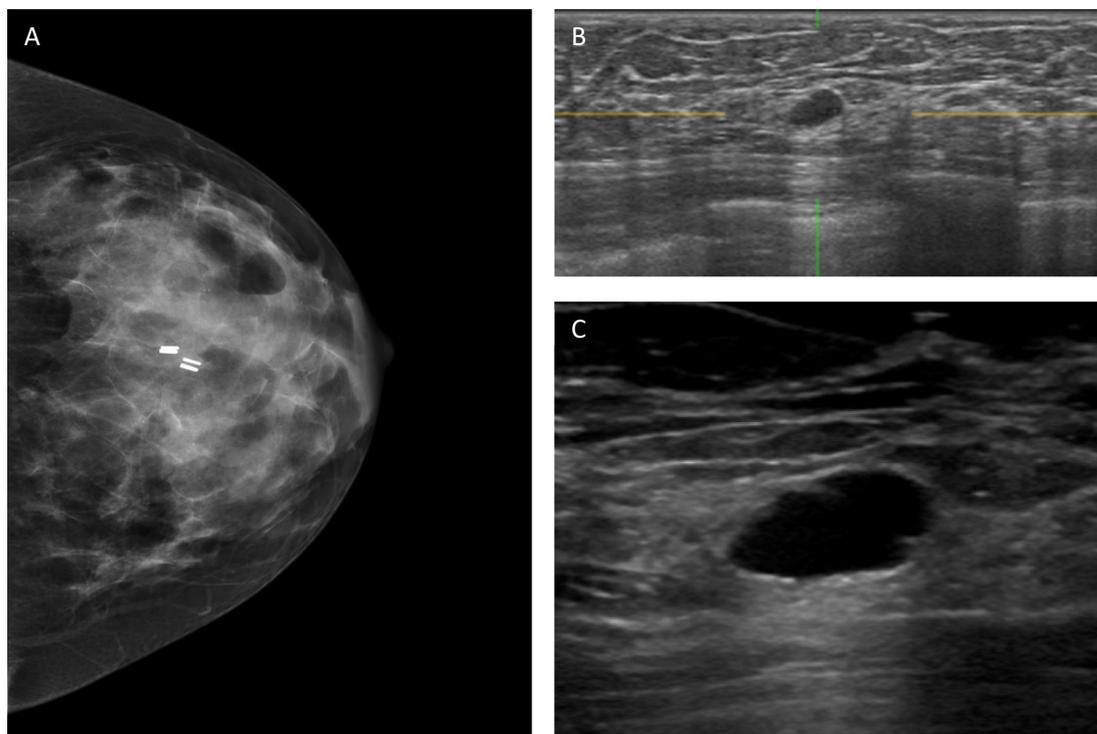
ABUS-only finding recalled with benign final assessment (patient 9). A) FFDM craniocaudal mammogram of the left breast. The breast is heterogeneously dense. There are clips from prior biopsy. No suspicious mass or calcifications. B) ABUS of the left breast showed an oval hypoechoic mass at 2:00. C) Targeted ultrasound of the left breast at 2:00 showed a lobulated simple anechoic cyst with an internal septation.
